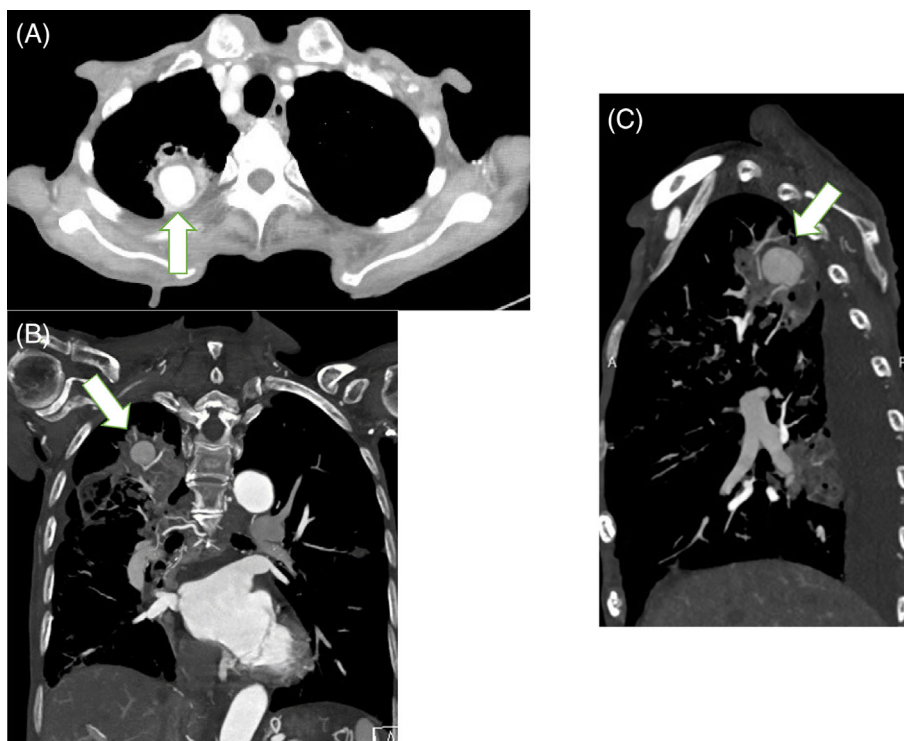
(A) Contrast-enhanced CT on admission showed pulmonary pseudoaneurysm in the right upper lobe (arrow), (B) Coronal CT section, and (C) Sagittal section
